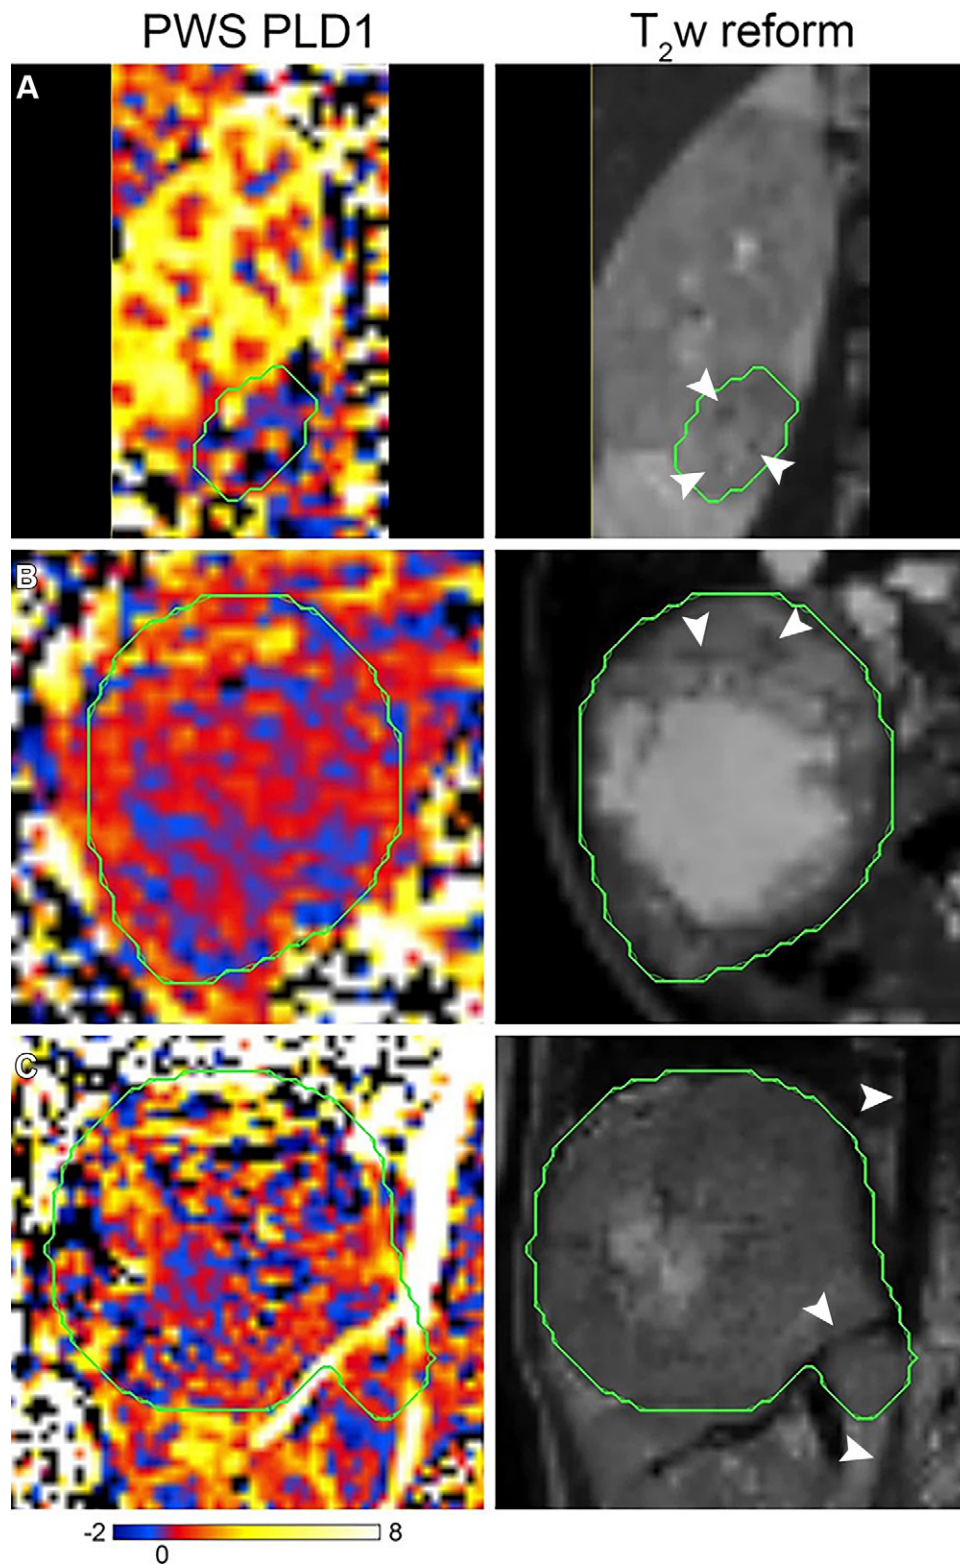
(A, B) Perfusion-weighted signal (PWS) and T2-weighted (T2W) images in an 8.3-year-old female patient and a 2.2-year-old female patient, respectively, with Wilms tumor. The images show that the high perfusion-weighted signal areas within the tumor correspond to the low signal intensity areas on the T2-weighted image (white arrowheads). (C) Perfusion-weighted signal and T2-weighted images in a 3.8-year-old male patient with neuroblastoma shows that the marked high-signal descending aorta and right renal artery on the perfusion-weighted signal image correspond to the regions on the T2-weighted image (white arrowheads). (Adapted, under a CC BY 4.0 license, from reference 47.)
